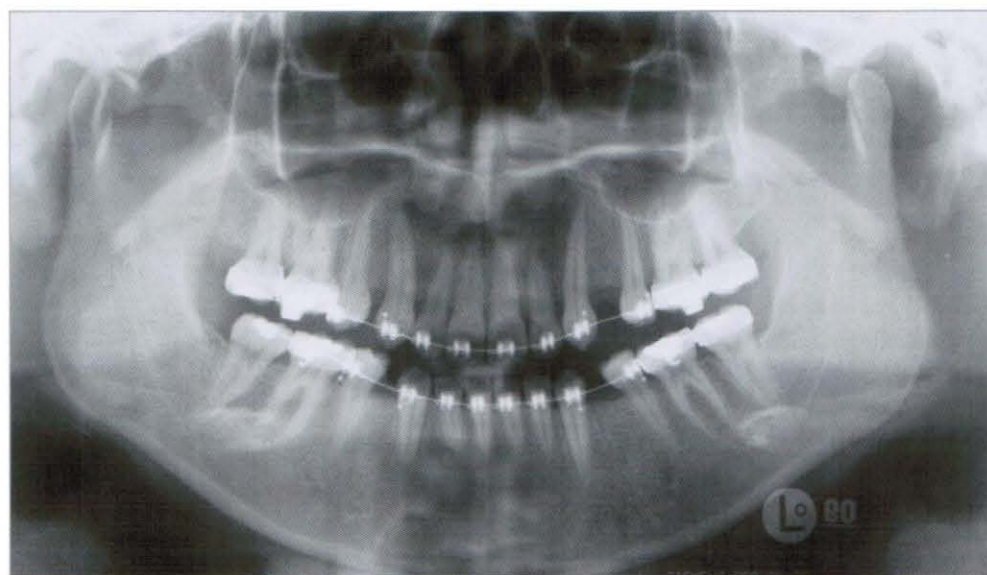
Panoramic radiograph taken after leveling up to 016x022" NiTi (2002,11,5)
